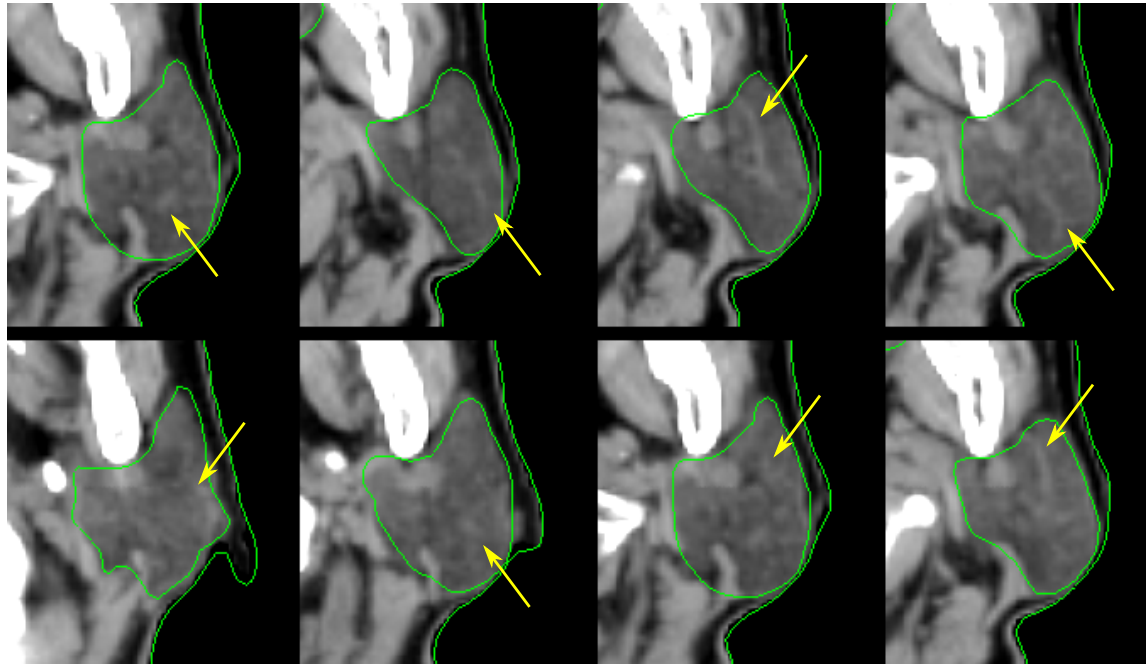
Example BCCA routine axial CT images (at 120 kVp and 350 mA) at various levels demonstrating visibility of sub-structures within the left parotid (variously indicated; all are most likely vasculature owing to the relatively low permeability of acinar cells to ioversol).
